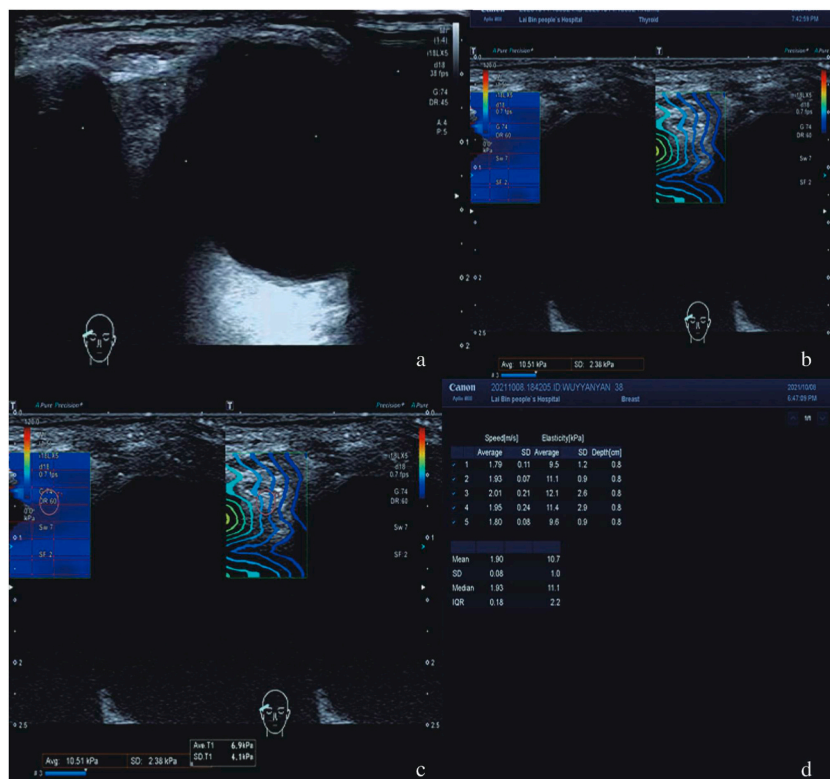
a Subjective visual symptom score value Level 2, LGUS lacrimal gland ultrasonography Level 2. b The glandular parenchyma area is filled with a color that is complete and stable. c In the SWE mode, the region of interest (ROI) is placed in the center of the sample box for measurement. d Median (median) Young's modulus Emean value of effective stiffness values measured five consecutive times in the right lacrimal gland.
